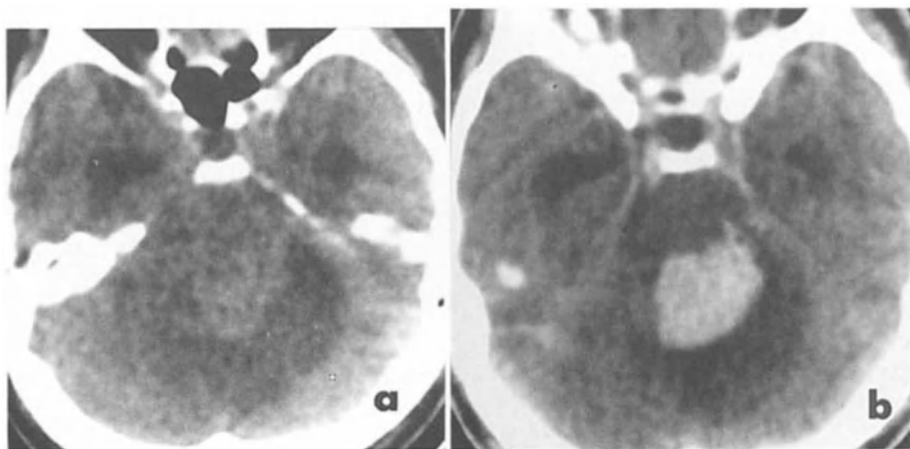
Solid cerebellar haemangioblastoma (type 3): CT appearance before (a) and after (b) iodine contrast medium infusion. Tumour is surrounded by focal oedema and appears spontaneously slightly denser than cerebellar normal tissue.
